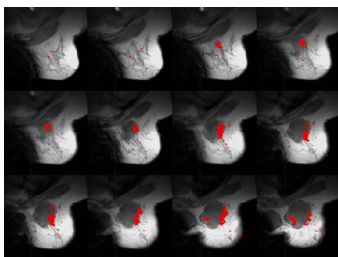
Montage of contrast enhanced T2 weighted MR images (left) and shear modulus elastograms (right) obtained from a patient with a locally advanced malignancy. The red arrows indicate areas of contrast enhancement.
